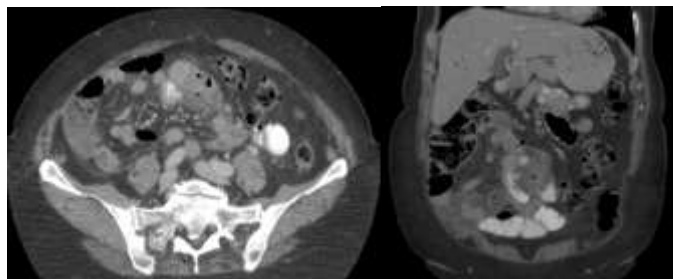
Portal venous phase CT of Jejunal diverticulitis (Case 2).
